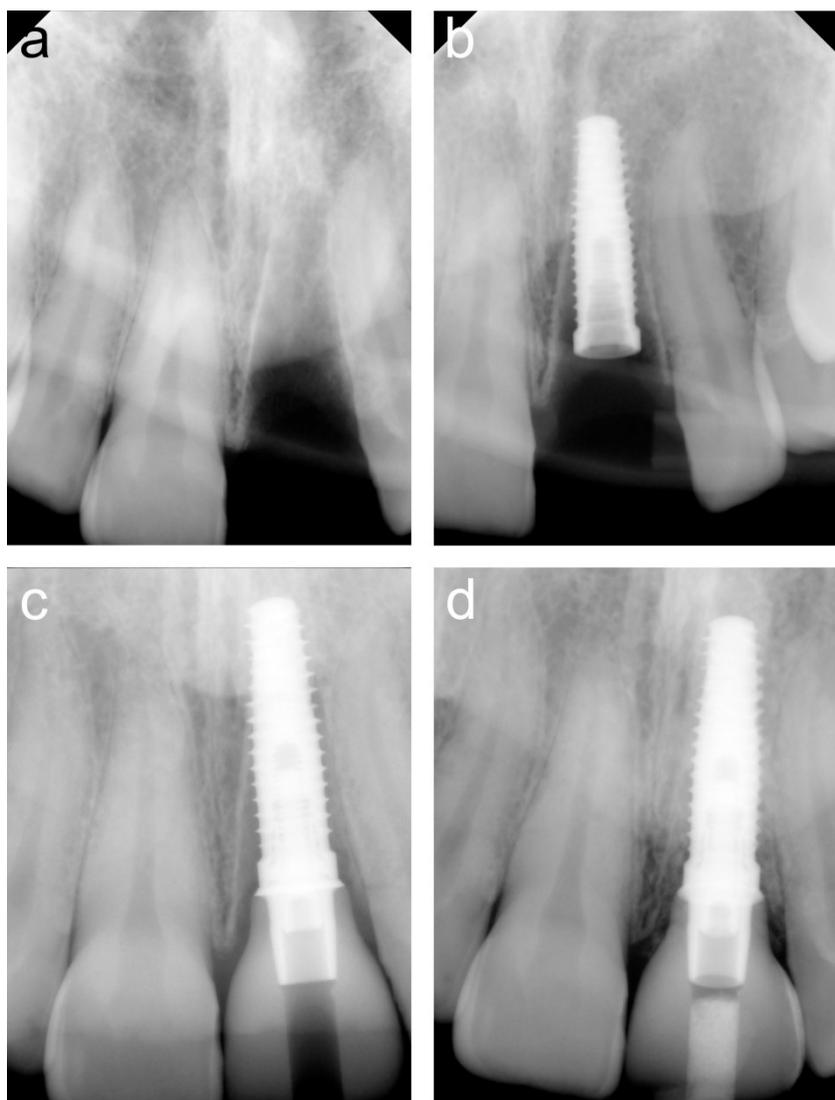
Radiographic appearance. 13a Extraction socket. 13b Immediate implant stabilized. 13c Custom provisional crown delivered. 13d Postoperative month three.
